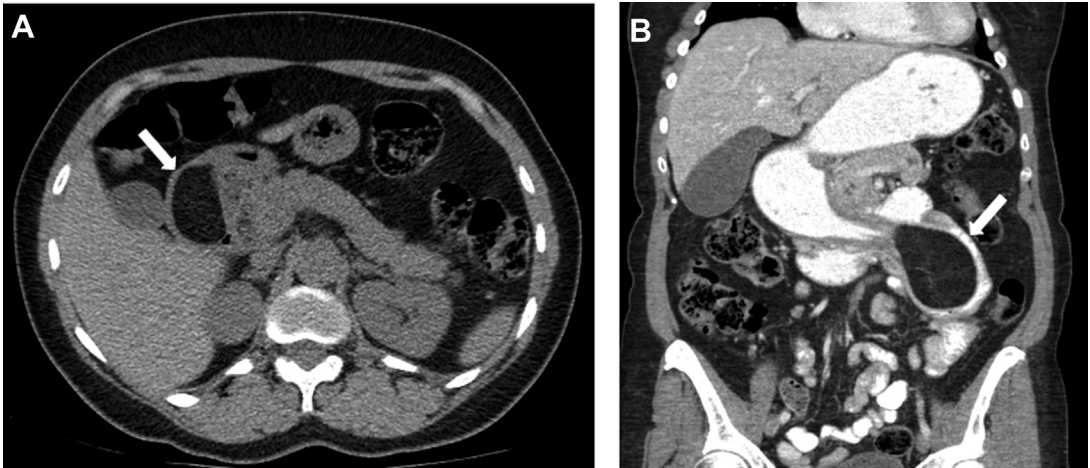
Intussuscepting duodenal lipoma. A 63-year-old woman (on initial presentation). (A) Axial image from chest CT performed with intravenous contrast to evaluate for a possible lung mass demonstrates an incidental lipoma (*arrow*) within the duodenal bulb. (B) Coronal image from without intravenous contrast-enhanced abdominal CT 3 years later, after the patient presented with abdominal pain, now shows duodenal intussusception into the proximal jejunum with the lipoma increased in size, and now serving as lead point (*arrow*).
